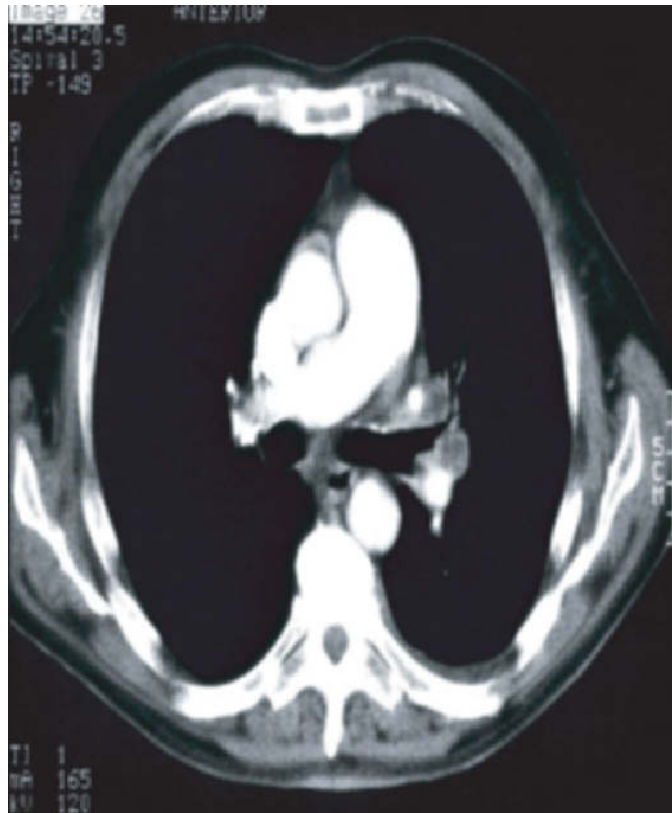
Computed tomography scan of left hilar adenopathy.
